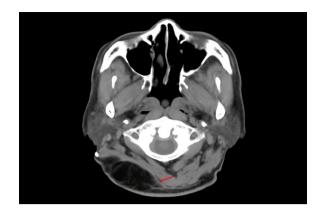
Shaggy appearance of the tumor. Unenhanced CT scan shows a lipoma of the posterior neck. The interface between the tumor and its surrounding tissue (red arrow) has a shaggy appearance that is a sign of inflammation
